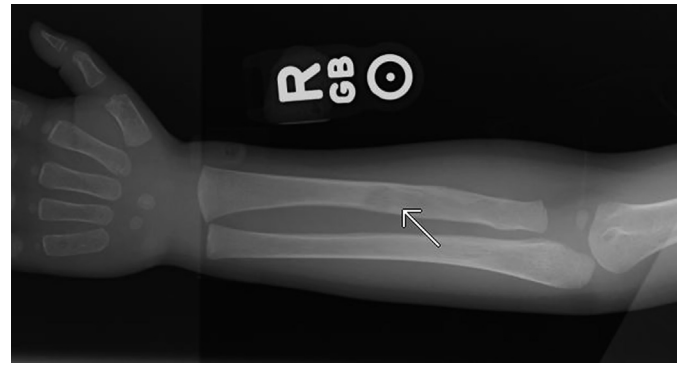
Right forearm radiograph. There is a lucent lesion in the mid-diaphysis of the radius without sclerotic rim (arrow). No periosteal reaction is noted.
